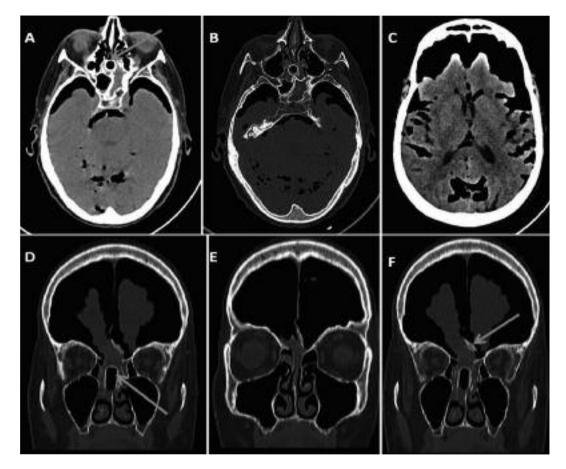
Cerebral CT-scans without contrast showing (A) the hollow foreign body (arrow) incarcerated in the cribriform plate of ethmoid bone with intact orbital walls; (B) foreign body with intact maxillary sinus walls; (C) significant pneumoencephaly in the bifronto-parieto-temporo-occipital lobes with mass effect; (D) the retained ethmoid hollow foreign body (arrow) with intact nasal concha; (E) intact orbital walls with absence of extraocular muscles incarceration and (F) fracture and displacement of *crista galli* (arrow).
